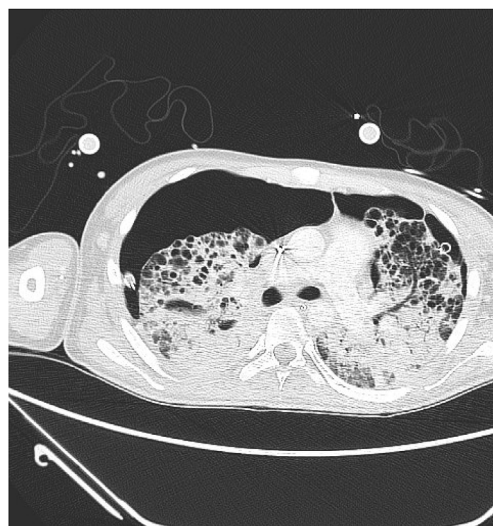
A CT scan after two weeks on VV-ECMO. Both lungs show numerous bullae and there were persistent bilateral pneumothoraces despite pleural tubes in-situ.
